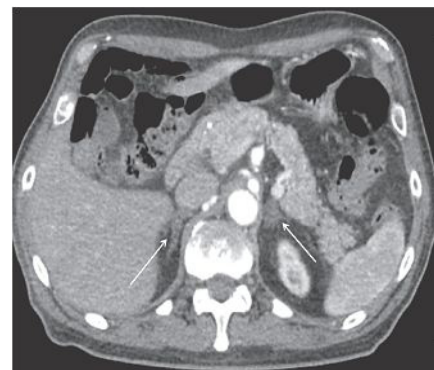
Follow up CT shows decreasing adrenal size with persistent thickening of both adrenal glands.
